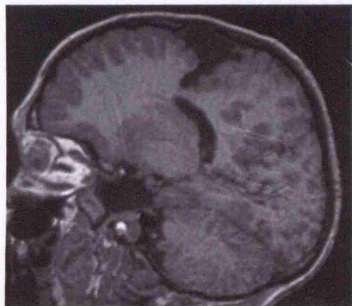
T1 weighted sagittal MR image. Subject JW. Bilateral schizencephaly, adjacent polymicrogyria, small body of the corpus callosum. The hippocampi, bilaterally small, are not visible on this slice.
